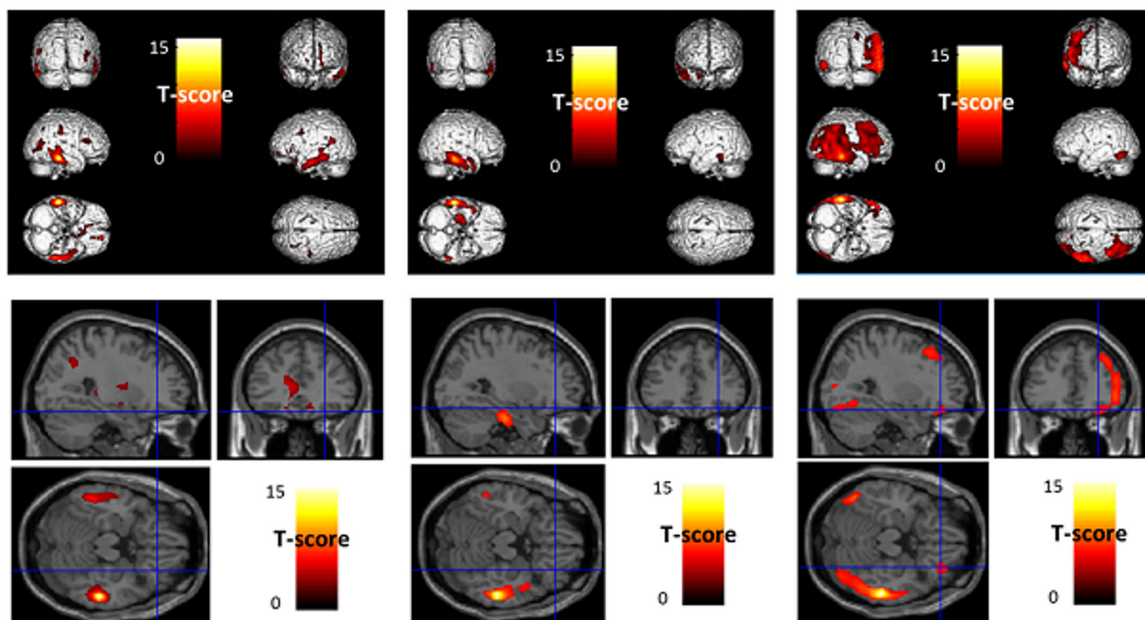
Anatomical localization of areas of increased positive right BA20–21 connectivity in healthy controls (left panel), in patients without ICDs (middle panel) and in patients with ICDs (right panel), projected onto 3D volume rendering (upper panel) and sections of a normal MRI (lower panel) set spatially normalized and smoothed into the standard SPM8 template ($p < .005$, uncorrected, $k > 130$). Healthy controls and patients without ICDs showed a moderately quite similar connectivity pattern involving bilateral temporal lobes (left and middle upper panel). Additional connectivity was only found in healthy subjects for fronto-parietal regions (left upper panel), without extension to orbito-frontal area (left lower panel). On the other hand, patients with ICDs showed a diffuse connectivity in bilateral posterior temporal lobes and right fronto-parietal lobes (right upper panel) including the orbito-frontal area (right lower panel). BA: Brodmann area; ICD: impulse control disorder; MRI: magnetic resonance imaging [Color figure can be viewed at wileyonlinelibrary.com]
